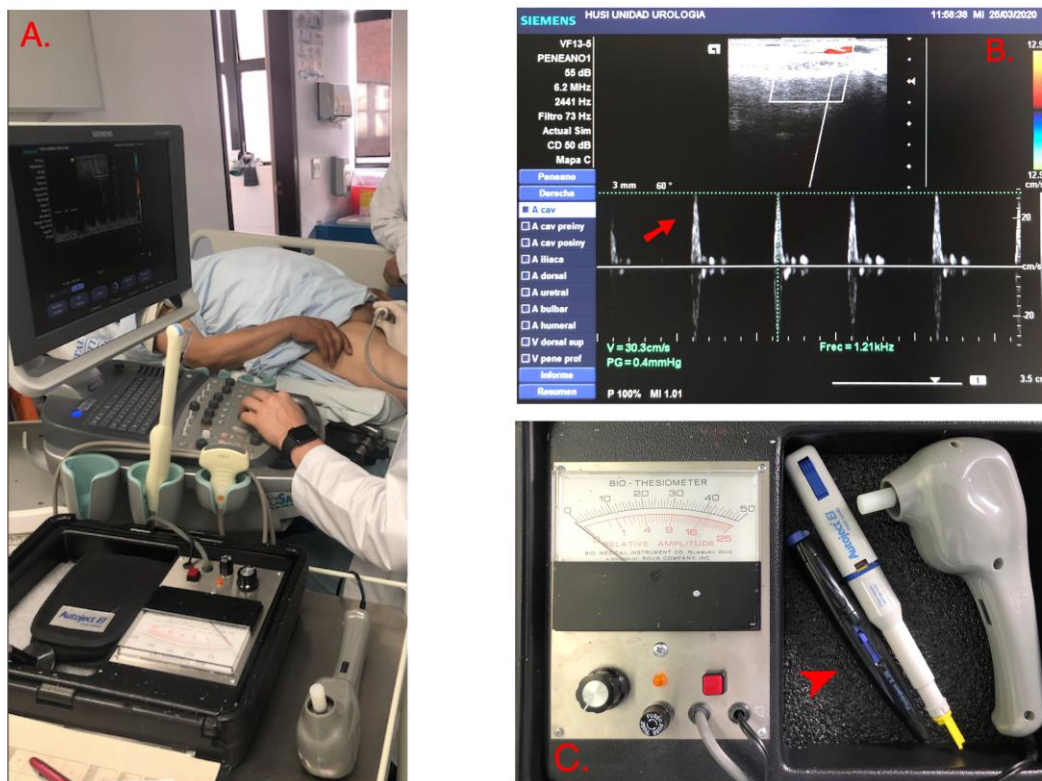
A. Room set up for the *CompED* test. B. Colour Duplex Doppler Ultrasound, with high-frequency linear array transducer 7.5 MHz, Penile flow velocities of the cavernosal artery were measured (Arrow) C. Biothesiometer manufactured by Bio-Medical instruments, Autoinjectors for the ICI (arrow head).
